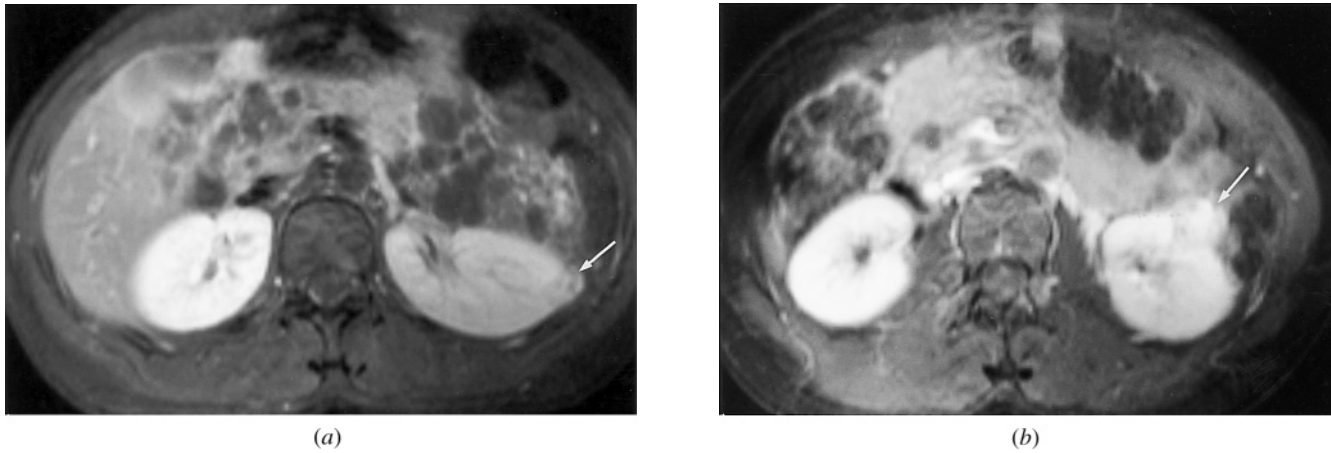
von Hippel-Lindau disease. T1-weighted fat suppressed gadolinium-enhanced SE images (*a, b*). Two small renal cancers are present in the middle (arrow, *a*) and lower (arrow, *b*) pole of the left kidney. Multiple pancreatic cysts are also appreciated (*a*).
